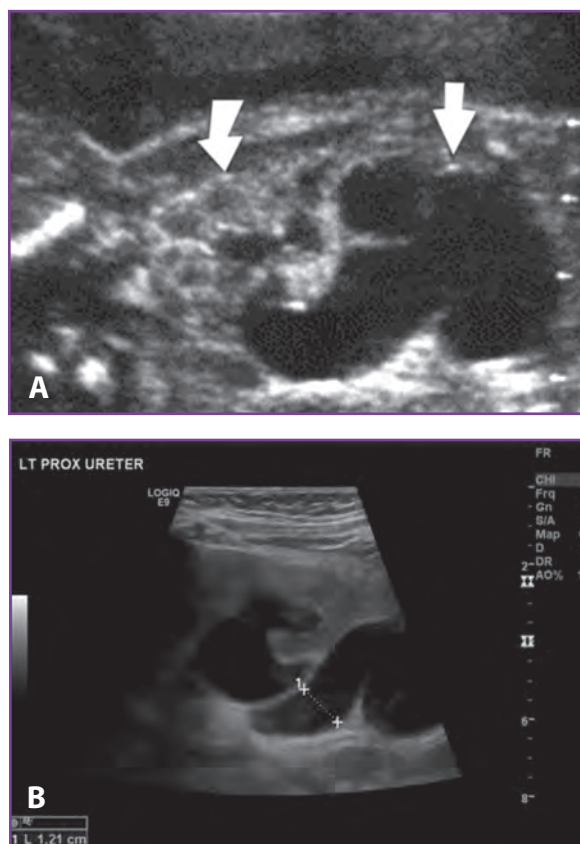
A, Prenatal ultrasonography (US) demonstrates a dilated kidney and ureter, also known as a *congenital megaureter*. B, Postnatal US shows a dilated ureter measuring 1.21 cm in diameter, behind the bladder.
